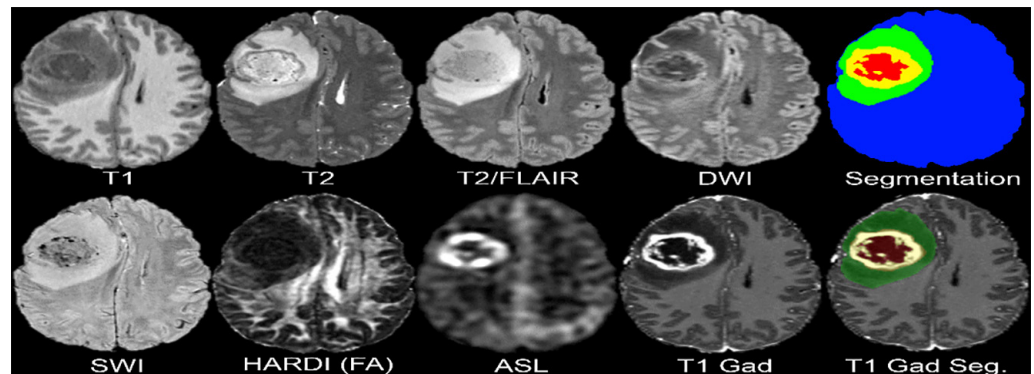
MRI modalities and tumor segmentation from preoperative imaging using a 3.0 tesla scanner [23]
